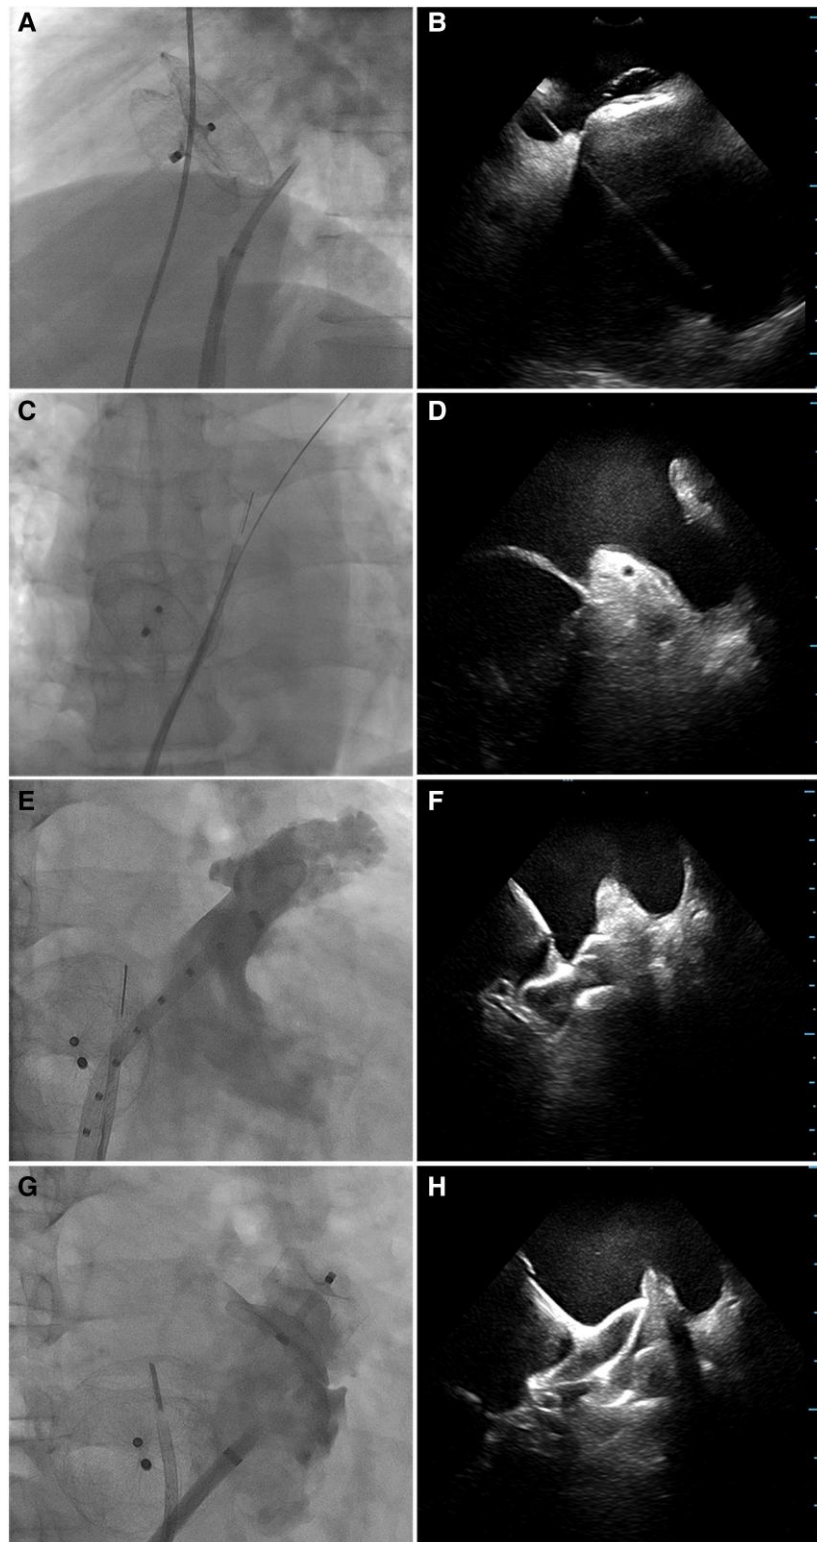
Intraprocedural fluoroscopic and intracardiac echocardiography images. (A) Fluoroscopic visualization of the Amplatzer Septal Occluder device and the Agilis NxT sheath with the transseptal system positioned inferiorly to the device. (B) The corresponding intracardiac echocardiography image after transseptal puncture with the GW002 wire in the left upper pulmonary vein. (C) The intracardiac echocardiography probe is advanced into the left atrium and positioned at the entrance of the left upper pulmonary vein. (D) The corresponding intracardiac echocardiography view of the left atrial appendage for procedural guidance. (E) Selective left atrial appendage angiogram before device deployment. (F and H) Intracardiac echocardiography images during device deployment. (G) Final angiogram with contrast injection after device release.
